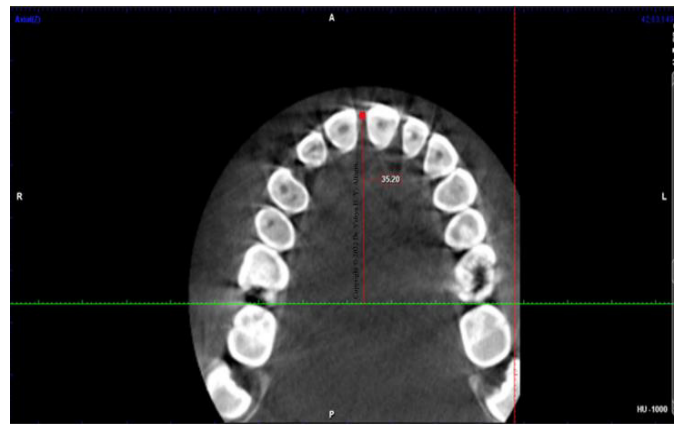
A CBCT image shows the reference lines for measuring arch length, the perpendicular distance from the tangent drawn on the distal aspect of the first permanent molar to the contact point of right and left central incisor teeth in the axial view.
